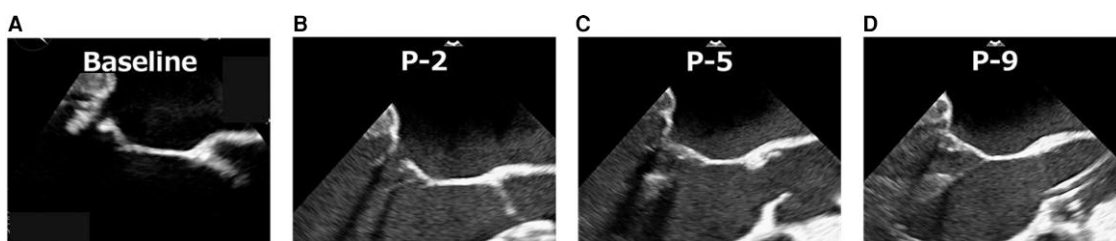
Transoesophageal echocardiographic findings of mitral valve coaptation at each Impella support level in Patient 1. Before Impella insertion (A) and at Impella P-2 support (B), there was a large junction gap. When the support level was increased (C, P-5; D, P-9), the junction of both leaflets coapted, although the tethering of the posterior leaflet remained unchanged.
